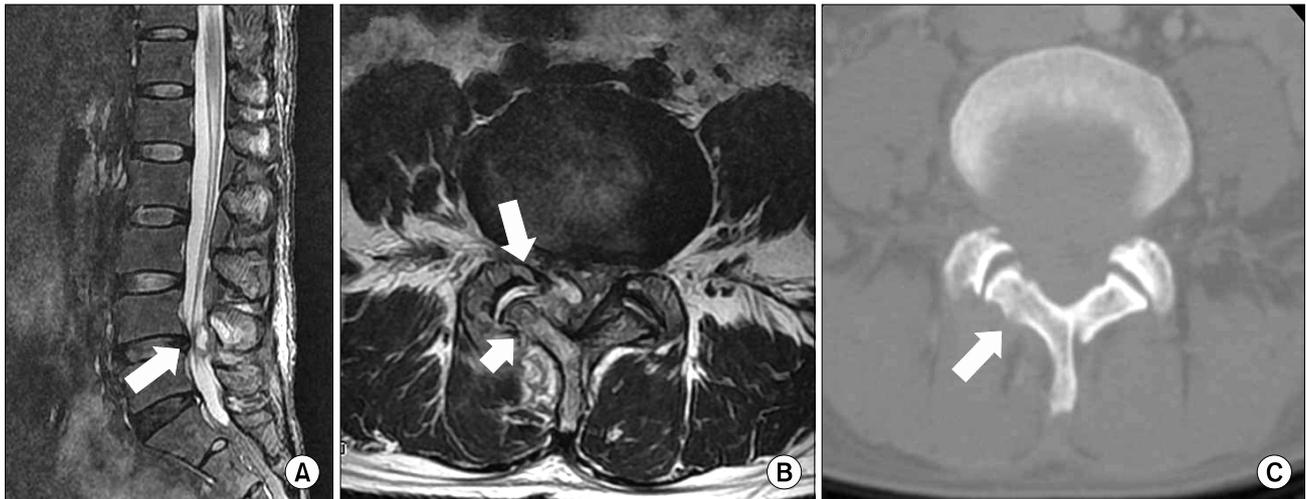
Preoperative images of the lumbar spine. Preoperative sagittal (A) and axial (B) magnetic resonance images show a large, round, mass-like lesion with heterogeneous signal intensity on the T2-weighted image. The right facet joint shows fluid accumulation (B, upper arrow). Laminal fracture close to the L4-5 facet joint is also seen (B, lower arrow). A preoperative computed tomography scan of the lumbar spine at the L-5 level shows a laminar fracture close to the L4-5 facet joint on the right side (arrow).
